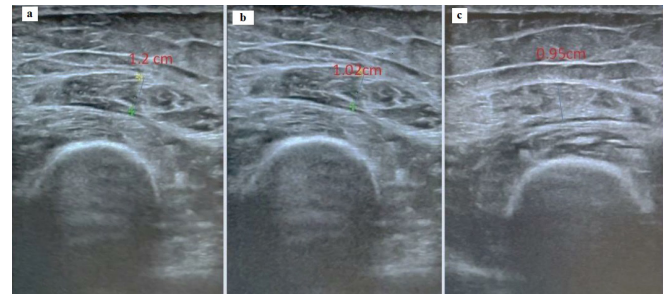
Representative ultrasound sonography image of muscle mass measurement.
